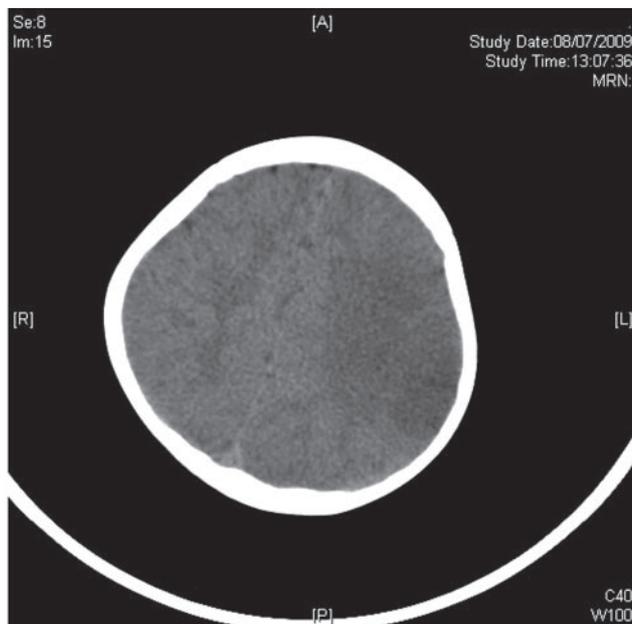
CT Brain. Wedge shaped hypodensity involving grey and white matter was seen at left MCA territory.
